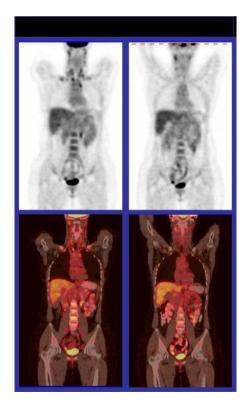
FDG images on the left show brown fat uptake. FDG images on the right do not show brown fat uptake after administration of benzodiazepines.
